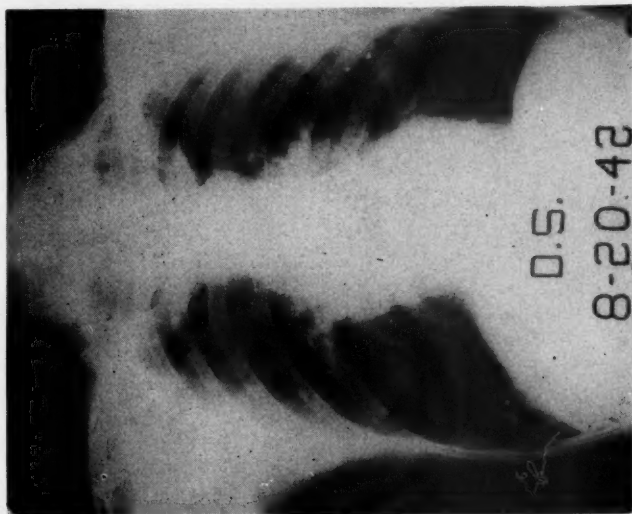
Roentgenogram of chest showing circumscribed opacity projecting out from right hilum. Pneumonectomy. Carcinoma of bronchus. Four and one half year survival.
